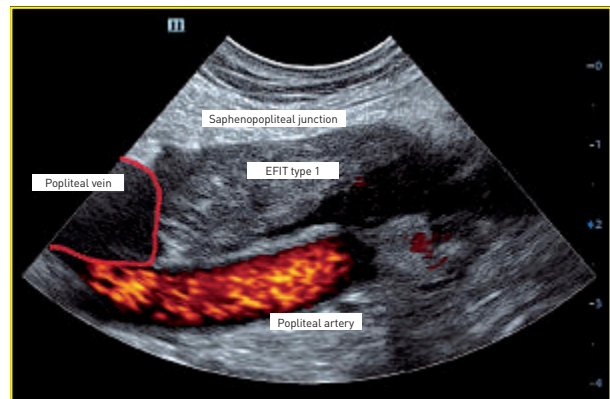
EFIT type 1, seven days after ultrasound-sclerotherapy with foam of a SSV.
